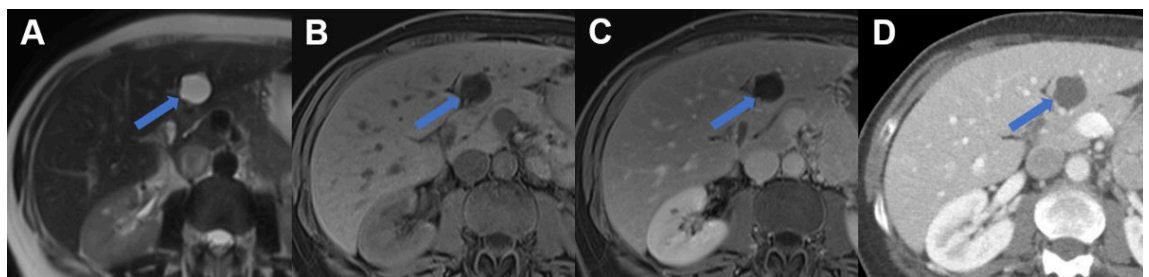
Liver cyst on MRI and CT. Typical liver cyst in segment III with A hyperintense signal on T2 weighted MR image, B hypointense signal on T1 weighted MR image, and C lack of enhancement on portal venous MR. D On CT the cyst appears sharply demarcated with fluid attenuation and lack of enhancement.
